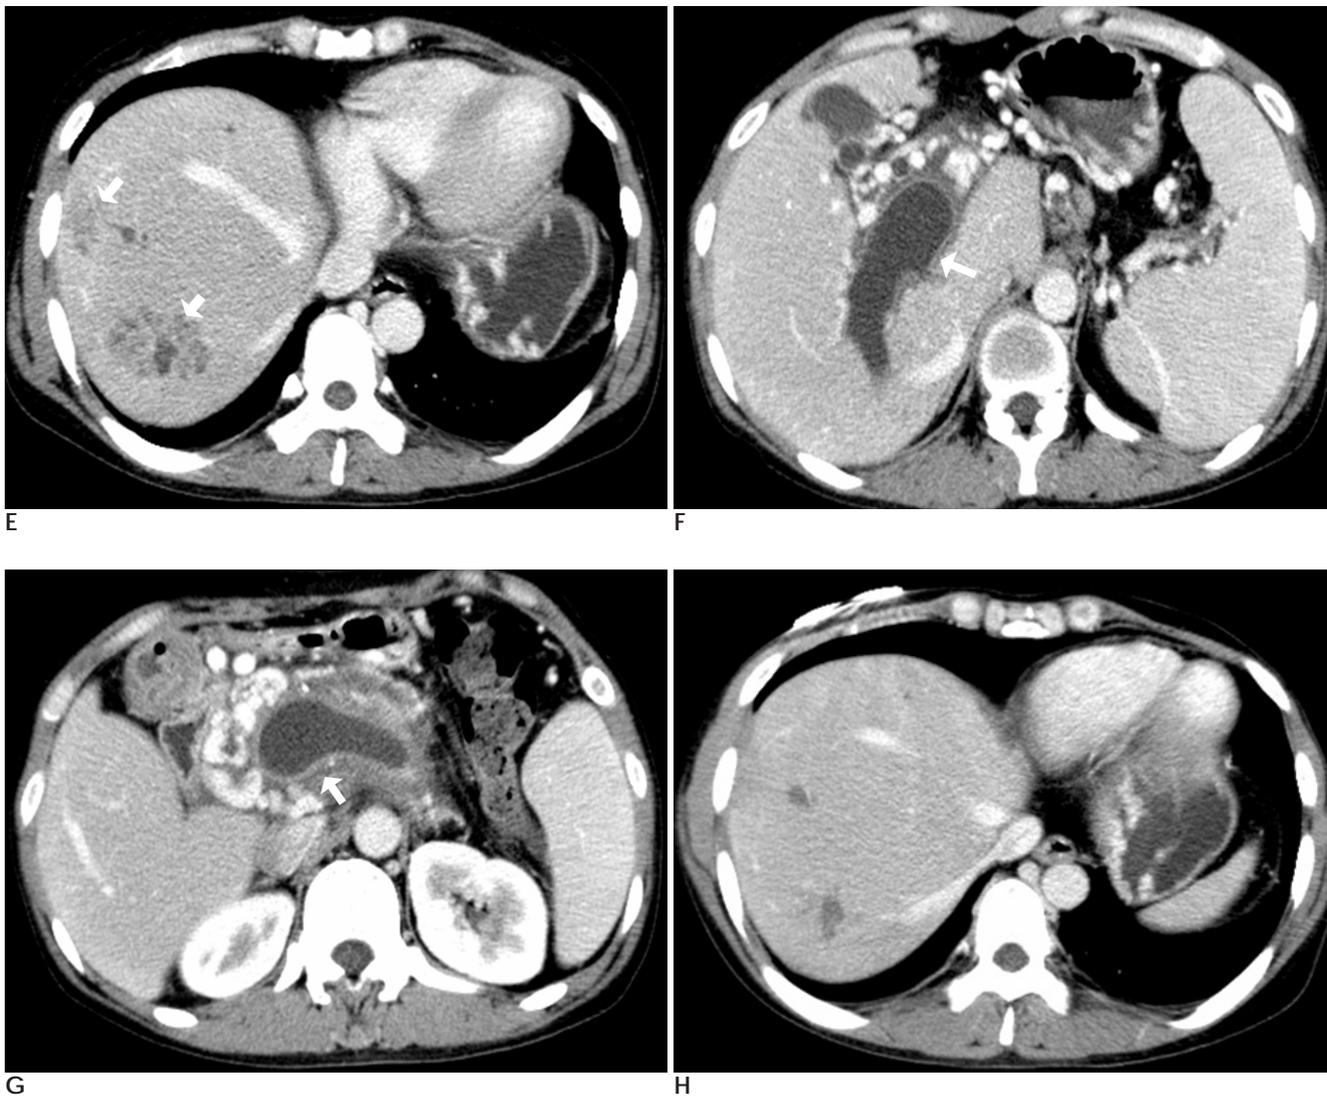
E. Two clustered small low density lesions (arrows) are noted at the right hepatic lobe surrounding thrombosed S8 portal vein, which was interpreted as liver abscesses on a portal venous phase CT scan. F. The portal venous phase CT scan conducted two weeks after medical treatment shows the disappeared hepatic artery pseudoaneurysm at the thrombosed right portal vein (arrow). G. The portal venous phase CT scan conducted two weeks after medical treatment indicates that the previously identified thrombosis at the portal-splenic vein is liquefied and has a decreased diameter at the main portal vein (arrow). H. The last follow-up portal venous phase CT scan conducted 4 weeks after medical treatment reveals an improvement in the previously identified liver abscesses.
